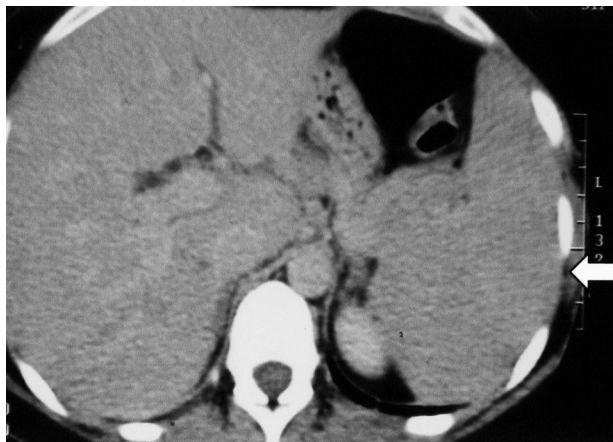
Abdominal computed tomographic scan demonstrating moderate splenomegaly.
